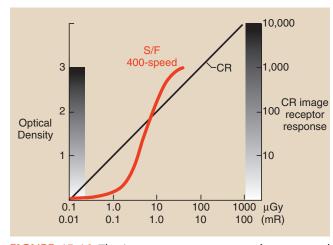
The image receptor response for computed radiography (CR) is shown with the characteristic curve of a screen-film image receptor.
